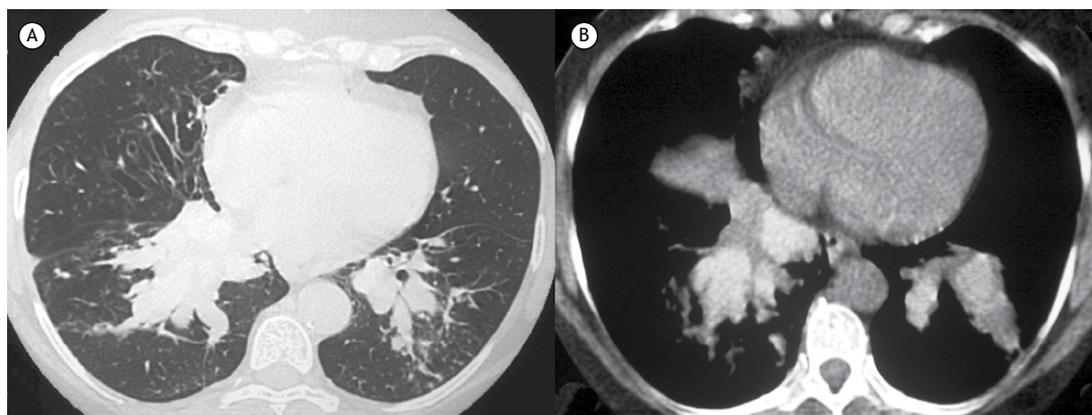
Chest CT scan in lung and mediastinal windows (A and B, respectively) showing branching tubular opacities in both lower lobes. Bronchiectasis is also seen anteriorly. Note in B that the density of the branching opacities is greater than is that of the heart.
